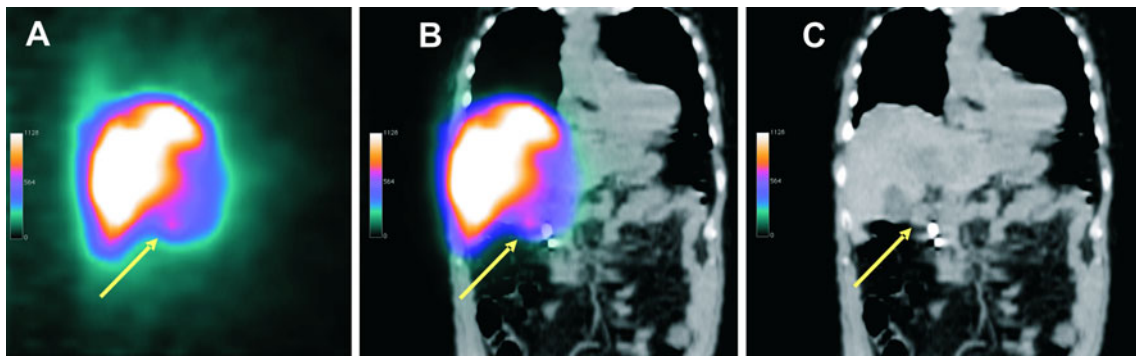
A 67-year-old patient with colorectal cancer. Coronal BS SPECT (a), BS SPECT/CT (b) and CT (c) images. RE was performed with 1.10 GBq resin microspheres without any complications during delivery. A focally increased accumulation in the duodenum is apparent and was reported as suspicious for extrahepatic shunting of ^{90}Y
